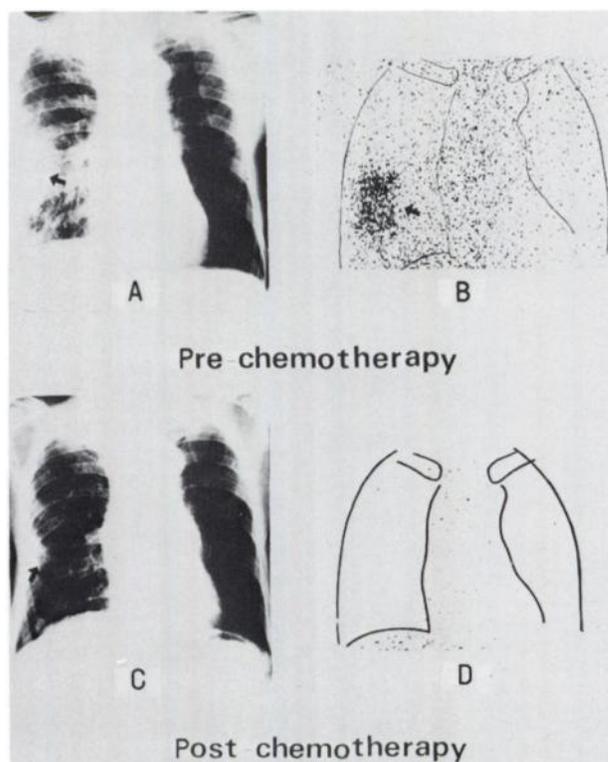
Case 4. Pulmonary tuberculosis. Chest x-ray (A) taken before chemotherapy shows productive shadow in right lower lobe. Gallium-67 scintigram (B) reveals positive scan corresponding to shadow in chest x-ray picture (indicated by arrow). Chest x-ray (C) and ^{67}Ga scintigram (D) were taken at time of completion of chemotherapy. Concentration of ^{67}Ga is greatly reduced due to effective treatment.
